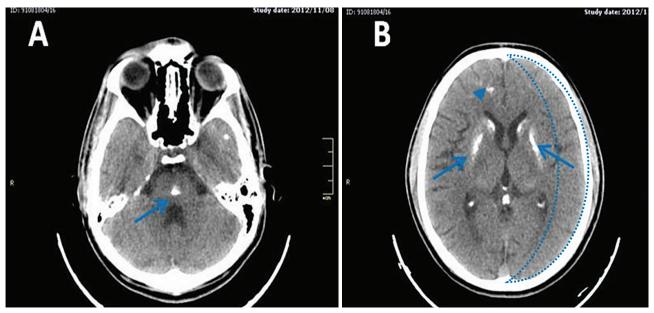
Axial noncontrast CT-scan of a 20 year-old man with MELAS syndrome demonstrates areas of calcification in the Pons (A), bilaterally symmetric calcification in the caudate and lentiform nuclei (arrows), corticomedullary junction (arrow head) and thalami in addition to mild gyral effacement in left side (en-dashes) (B).
